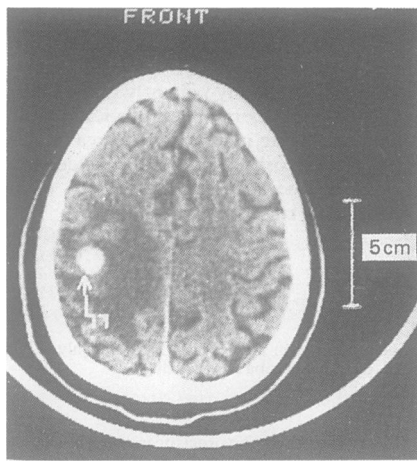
CT scan of head showing a left parietal enhancing disc shaped lesion.
